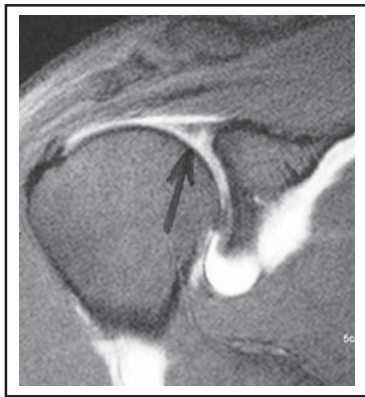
MRI-arthrogram images demonstrating a Type II SLAP tear. Note the irregular, laterally curved area of high signal intensity in the superior labrum
